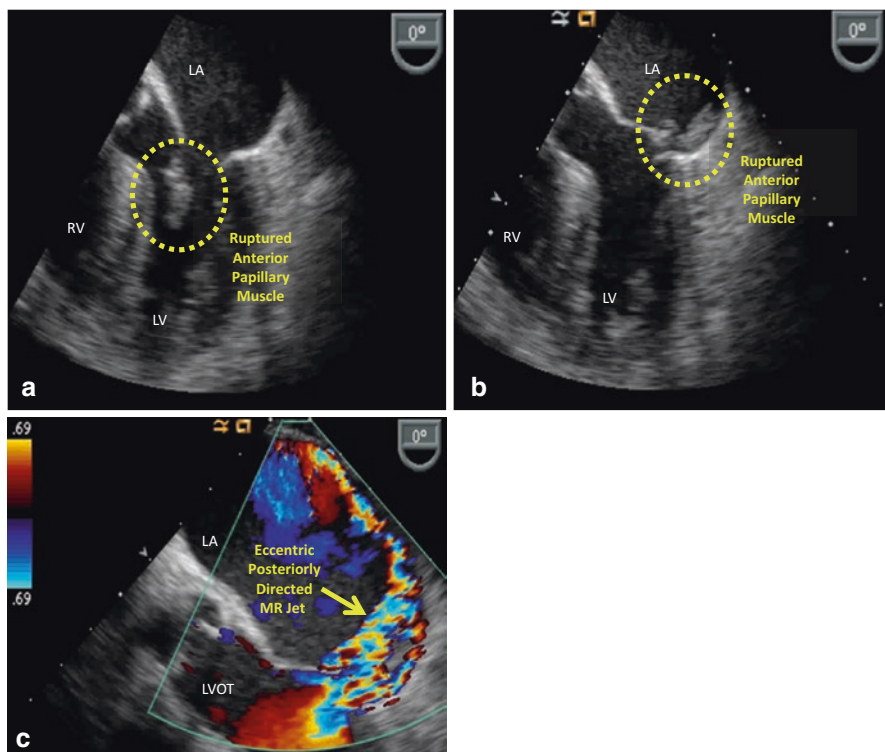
Ruptured anterior papillary muscle on TEE. Panel (a): Ruptured anterior papillary muscle in the left ventricle during diastole. Panel (b): Ruptured anterior papillary muscle in the left atrium during systole. Panel (c): Color Doppler imaging showing very severe eccentric, posteriorly directed, mitral regurgitation. In this condition, a murmur of severe acute mitral regurgitation may be heard. *Abbreviations:* LA left atrium, LV left ventricle, LVOT left ventricular outflow tract, MR mitral regurgitation, RV right ventricle
